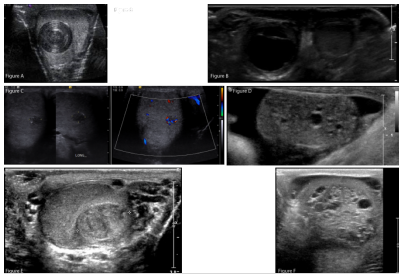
Representative sonographic images of a variety of pediatric testicular tumors. 3a) Sonographic image of epidermoid cyst in a pre-pubertal boy. 3b) Sonographic image of a teratoma in an infant. 3c) Sonographic image of a testicular leydig cell tumor in a peri-pubertal male. 3d) Sonographic image of a testicular granulosa cell tumor in an infant. 3e) Sonographic image of a pure embryonal carcinoma (non-seminoma) in a peri-pubertal male. 3f) Sonographic image of a mixed non-seminoma germ cell tumor in a pubertal male.
